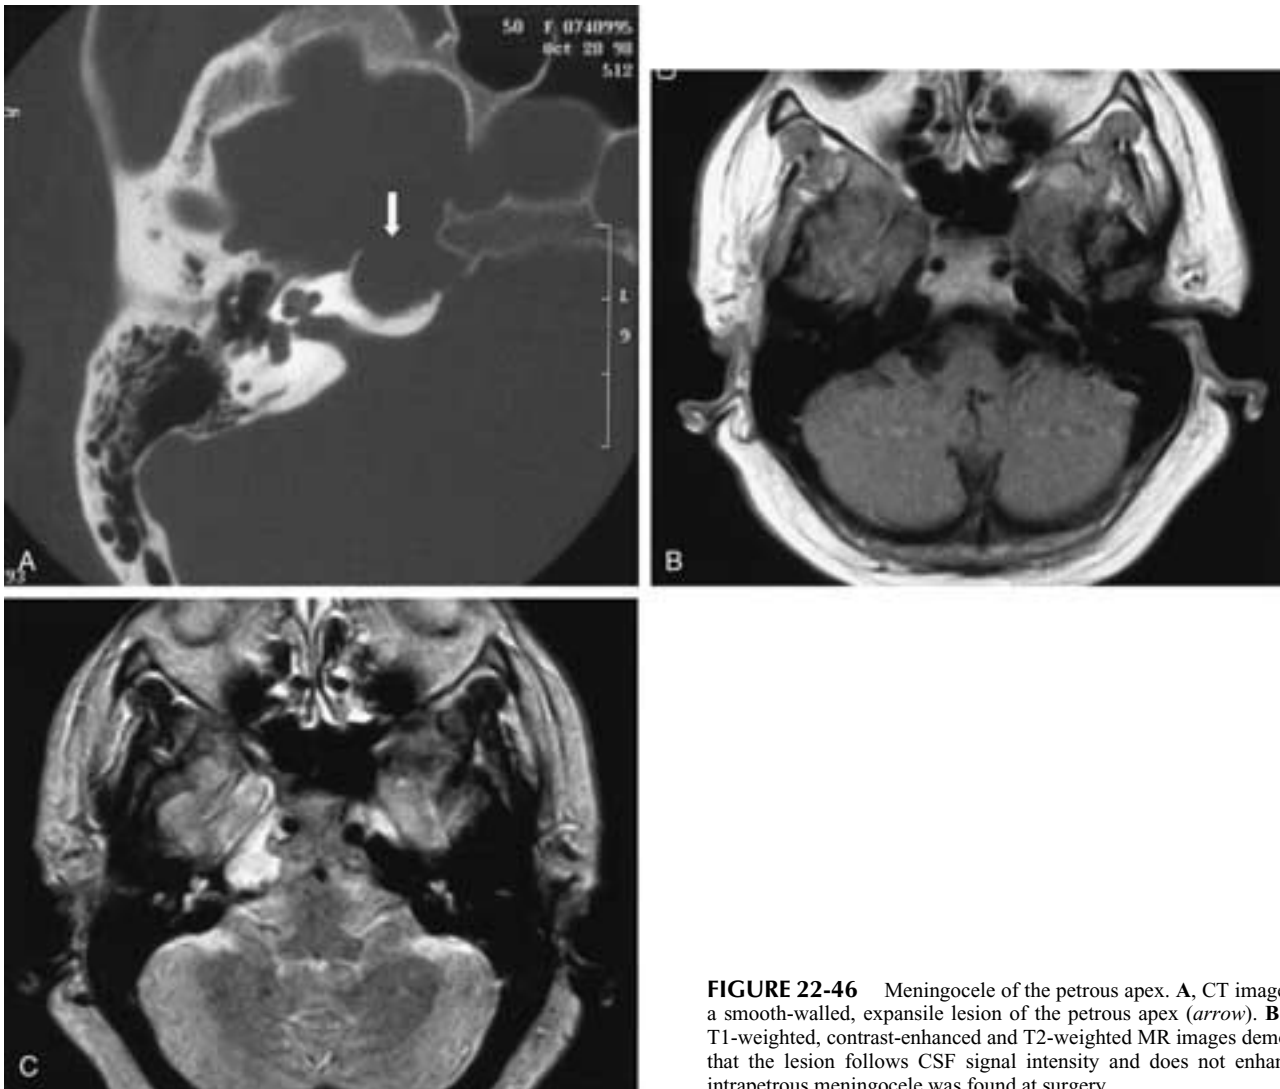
Meningocele of the petrous apex. A, CT image shows a smooth-walled, expansile lesion of the petrous apex (*arrow*). B and C, T1-weighted, contrast-enhanced and T2-weighted MR images demonstrate that the lesion follows CSF signal intensity and does not enhance. An intrapetrous meningocele was found at surgery.
